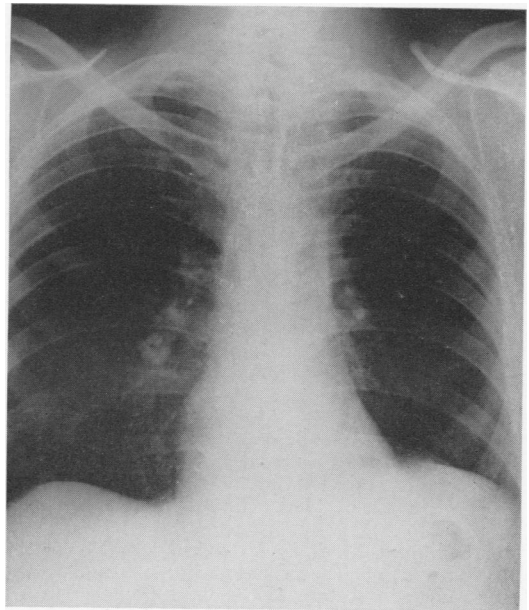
Essentially normal roentgenogram of the chest nine months after lobectomy.
